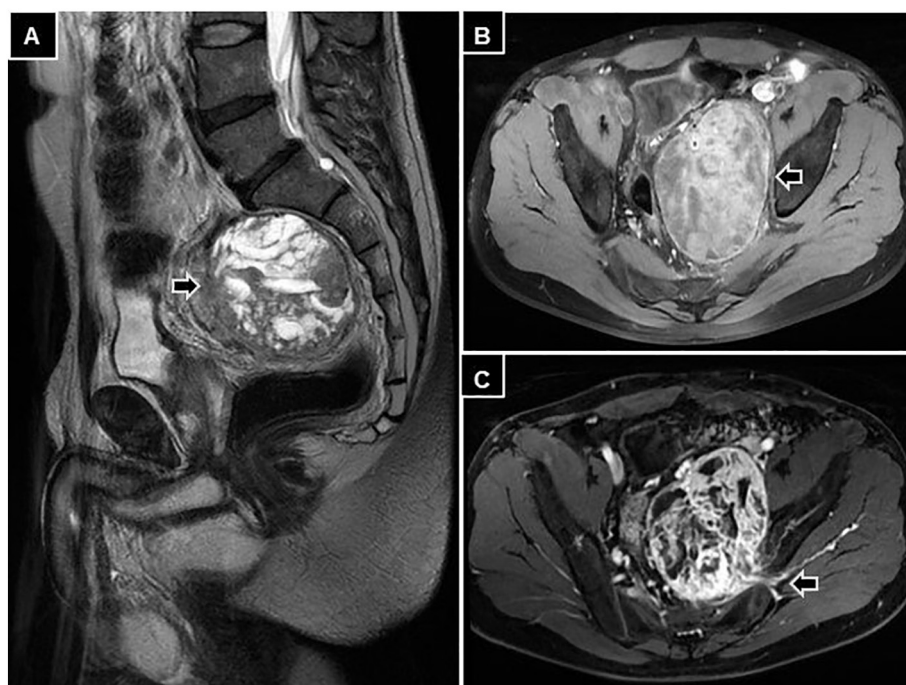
Abdominal and pelvic MRI. A: In sequence T2, a mass with presacral location is seen, with solid areas of intermediate signal intensity (black arrow). B: In sequence T1, heterogeneous lesion, well-defined borders, and hyperintense, with some trabecular areas (black arrow). C: It is noteworthy the development of pelvic collateral circulation and left gluteal vessel ingurgitation (black arrow).
